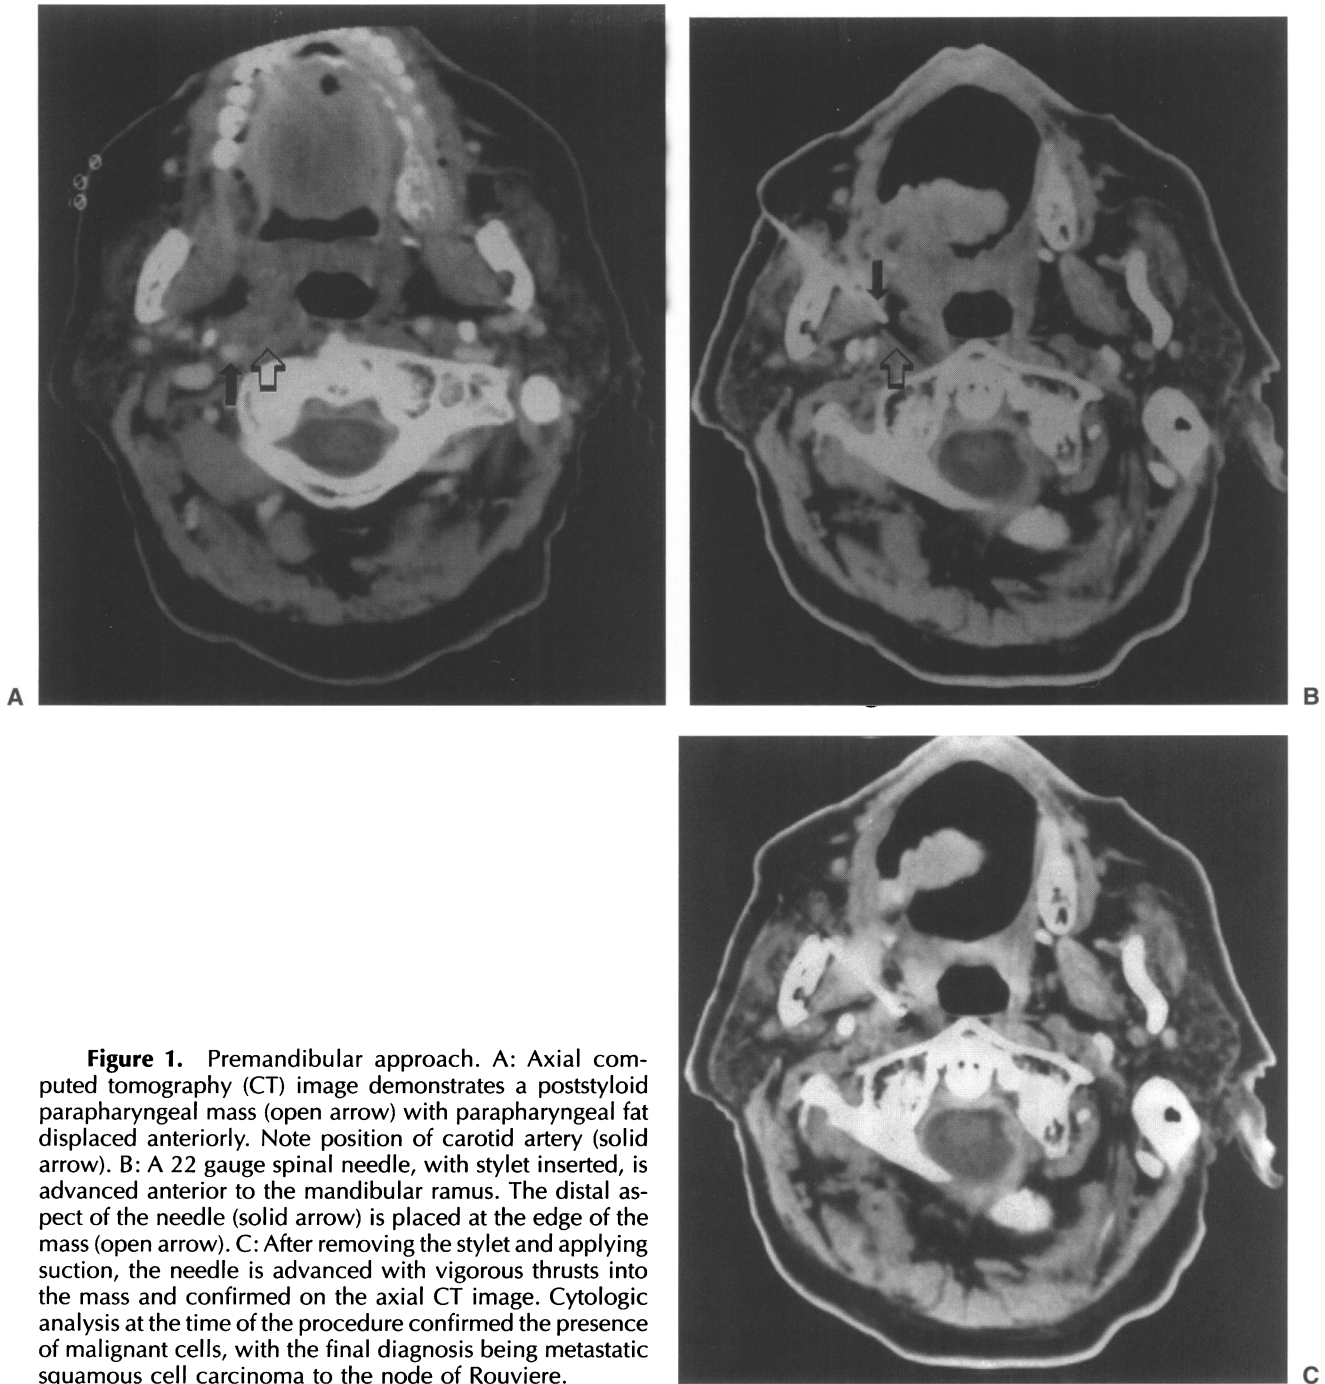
Premandibular approach. A: Axial computed tomography (CT) image demonstrates a poststyloid parapharyngeal mass (open arrow) with parapharyngeal fat displaced anteriorly. Note position of carotid artery (solid arrow). B: A 22 gauge spinal needle, with stilet inserted, is advanced anterior to the mandibular ramus. The distal aspect of the needle (solid arrow) is placed at the edge of the mass (open arrow). C: After removing the stilet and applying suction, the needle is advanced with vigorous thrusts into the mass and confirmed on the axial CT image. Cytologic analysis at the time of the procedure confirmed the presence of malignant cells, with the final diagnosis being metastatic squamous cell carcinoma to the node of Rouviere.
